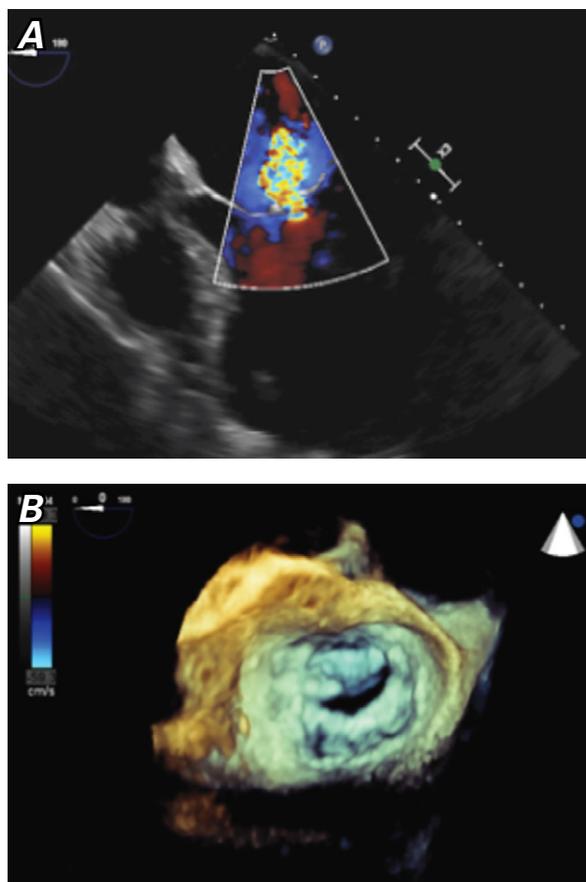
Initial transesophageal echocardiograms of the mitral valve in A) 2-dimensional and B) 3-dimensional views show a relative absence of calcification in the valve leaflets and apparatus, with the exception of a focal calcification in the posterior aspect of the annulus.
